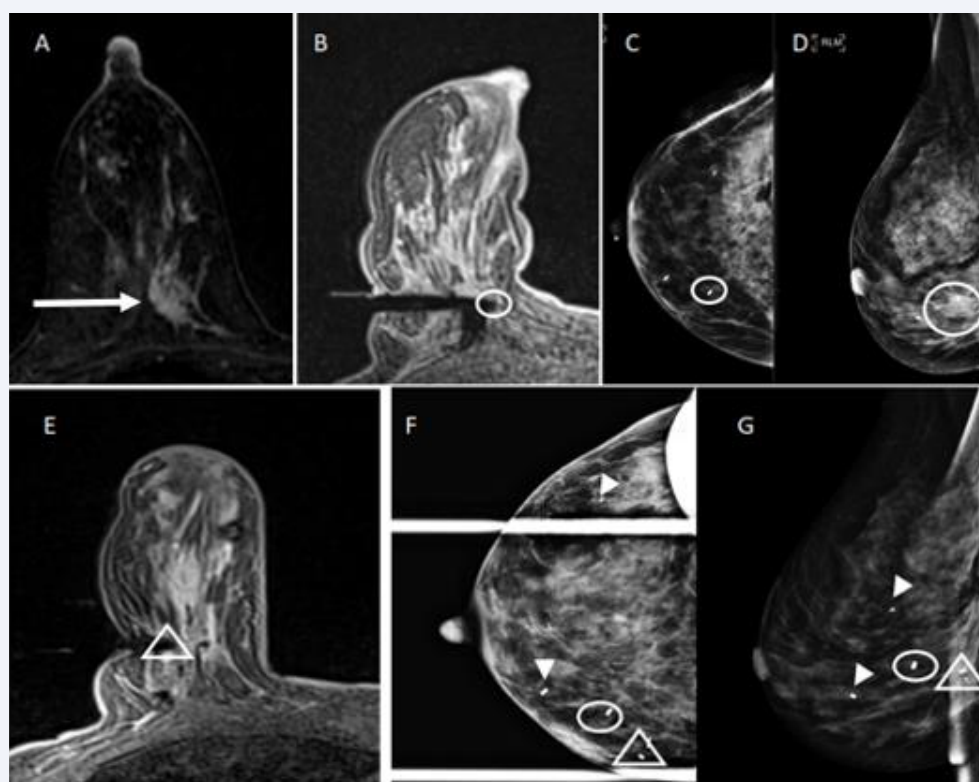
A: T1-weighted post-contrast subtraction MRI image demonstrates non-mass enhancement in the central right breast (arrow). B: MRI-guided core biopsy with clip marker placement (circle) showed carcinoma in situ with predominantly lobular features and focal pleomorphism. C and D: Craniocaudal and lateral post-clip mammography images show anterior and inferior migration of the post-biopsy clip (circle). Figure E: Subsequent MRI-guided clip marker images show satisfactory positioning of the clip marker into the area of non-mass enhancement targeted for initial biopsy (triangle). F and G: Post-clip mammography images following same day I125 radioactive seed insertion document appropriate positioning of the MRI clip marker and successful localization (triangle). The migrated clip marker is seen anteriorly and laterally (circle). Two clips from benign stereotactic biopsies are noted in the upper outer and lower inner quadrants (arrowhead). Final pathology showed pleomorphic LCIS with negative margins.
